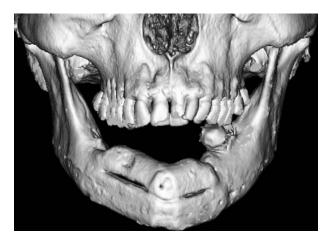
Postoperative three-dimensional CT findings at 2 years after removal of the titanium plates.
